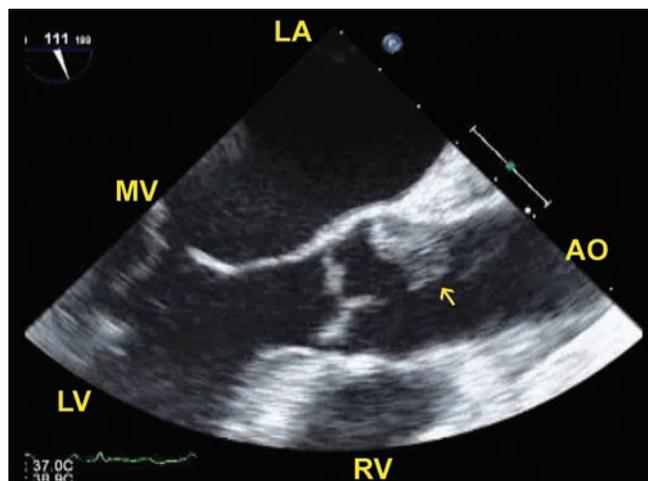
Transesophageal echocardiography showing a mass in the ascending aorta (arrow).
